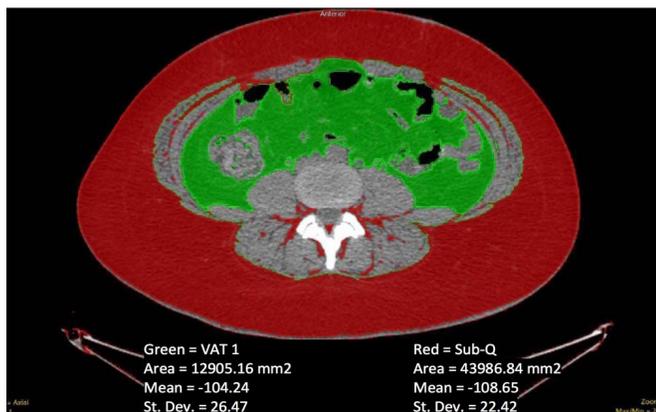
Axial CT slice at the level of the fourth and fifth lumbar vertebrae (L4-5).
